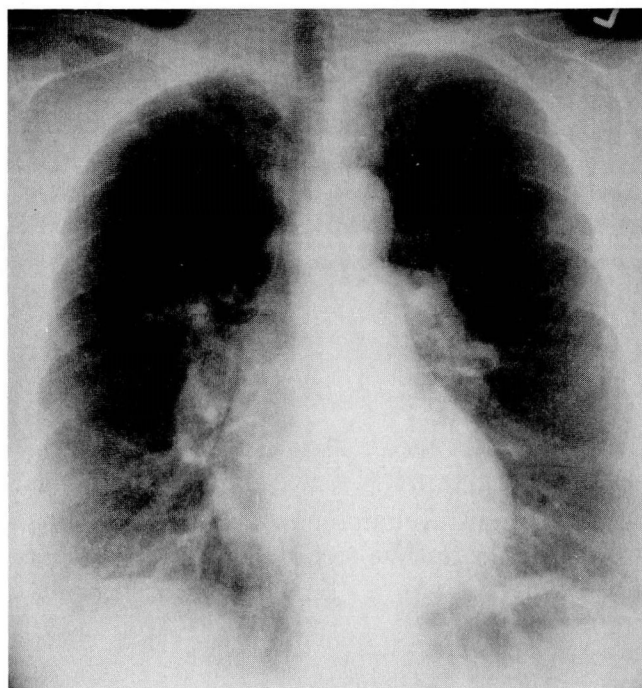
Posteroanterior chest radiograph demonstrating a right paraspinal mass lesion.
